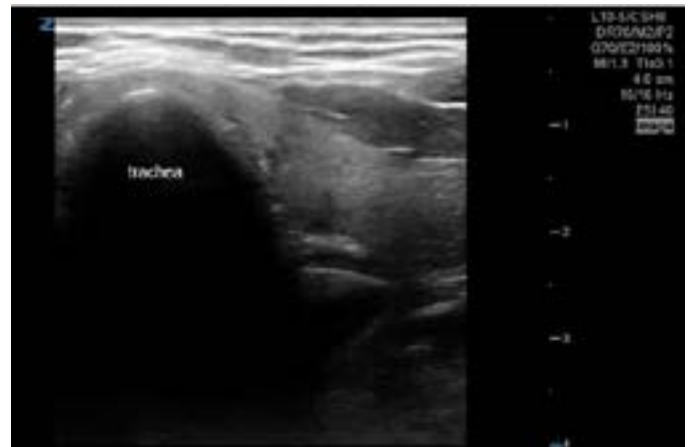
Ultrasound confirmation of a successful tracheal intubation.
